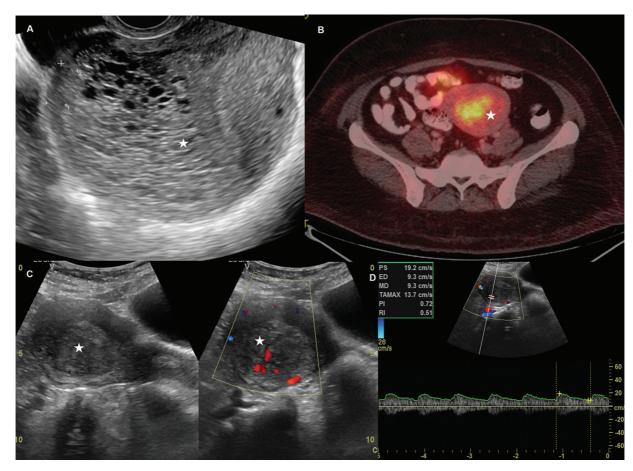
A 32-year-old woman with stage I choriocarcinoma. (A) Transvaginal scan at presentation showing mixed echogenic lesion with internal cystic spaces invading the myometrium in an enlarged uterus (★). (B) Axial fusion positron emission tomography (PET)/computed tomography (CT) image of the pelvis after 3 months of therapy shows hypermetabolic lesion in the uterus suggestive of residual malignancy. (C, D) Split-screen grayscale, color, and spectral Doppler ultrasound images show ill-defined heterogenous residual uterine mass with internal vascularity (★) exhibiting pulsatility index (PI) of <1.
